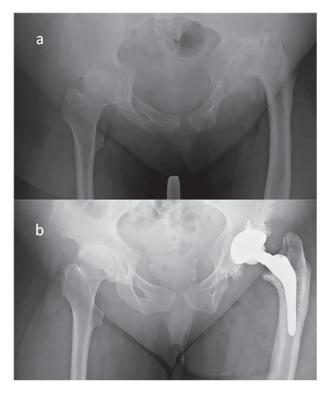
Fig 3a, 3b Pre-operative (a) and postoperative (b) anteroposterior pelvic radiograph of a 36-year-old woman with proximal femoral deformity and end stage coxarthrosis secondary to hip dysplasia.
